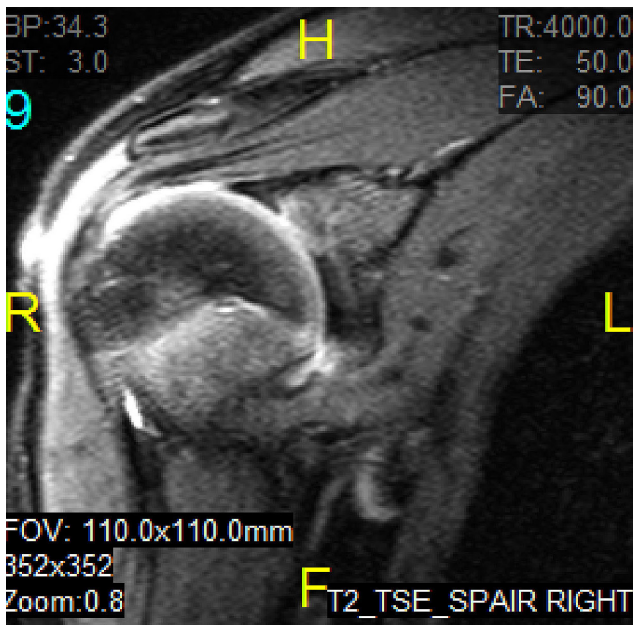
T₂-weighted coronal magnetic resonance imaging shows partial supraspinatus tear.
